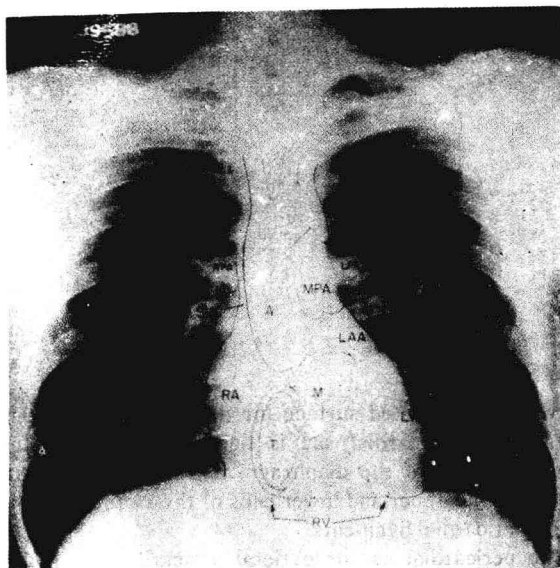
An x-ray of the chest with some cardiovascular landmarks indicated: RPA, right pulmonary artery; SVC, superior vena cava; RA, right atrium; A, aorta; T, tricuspid valve ring; MPA, main pulmonary artery; M, mitral valve ring; RV, right ventricle; LPA, left pulmonary artery; LAA, left auricular appendage; LV, left ventricle.
